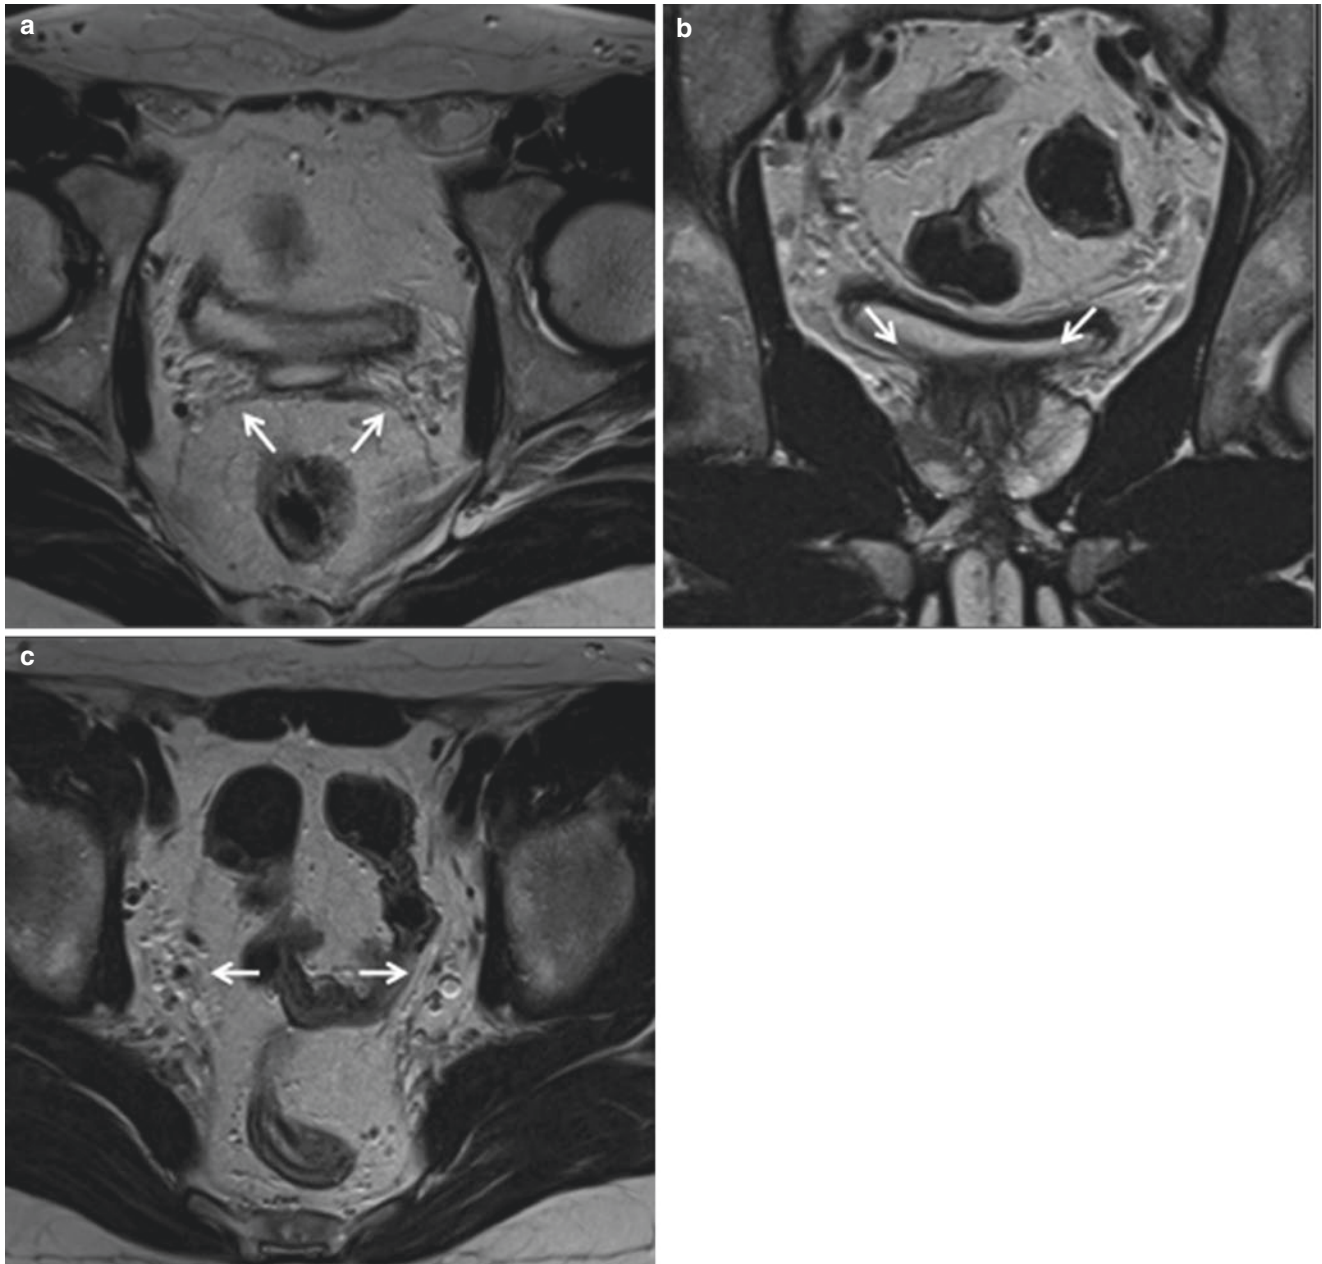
Agenesis of the SV and ED in a 26-year-old man with infertility. Axial (a) and coronal (b) T2-weighted MR image shows bilateral absence of the SV (arrows). Axial (c) T2-weighted MR image shows bilateral absence of the ED (arrows)
